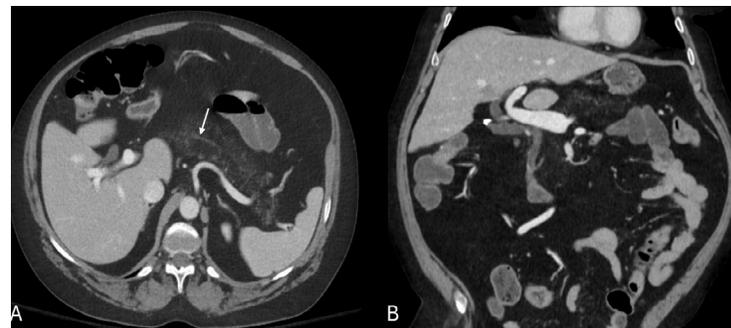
Computed tomography (CT) of the abdomen and pelvis with contrast obtained two months before Figure 1. (A) Axial and (B) coronal reformatted images demonstrate near-complete fatty replacement of the pancreas. The normal, non-dilated main duct is seen in the pancreatic body (white arrow).
